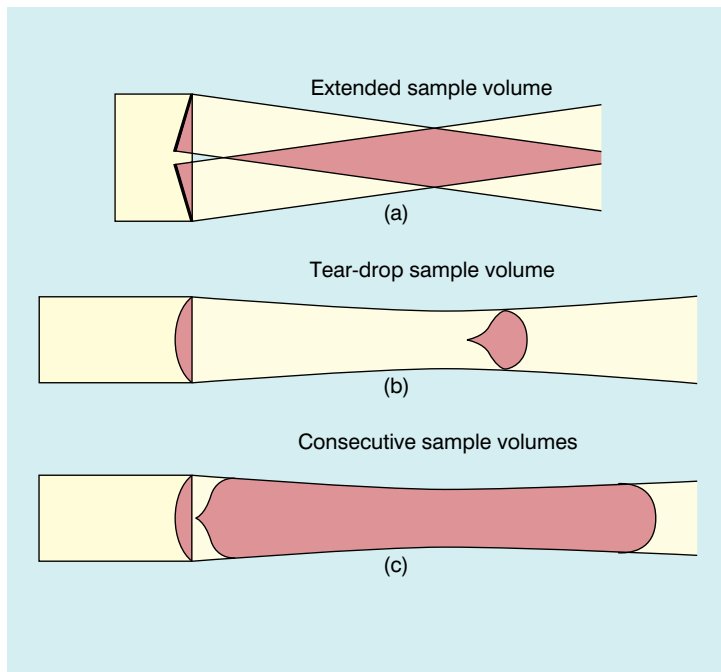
Sample volumes in Doppler techniques. (a) For dual crystal continuous wave Doppler unit. (b) For pulsed wave Doppler unit. (c) Neighbouring sample volumes along a beam for imaging Doppler units.
